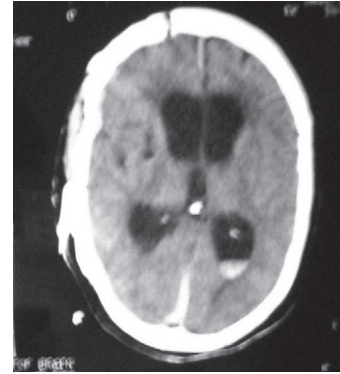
Non-contrast CT showing resolution of acute subdural hematoma and mass effect. There is increase in ventricular size with presence of intraventricular blood.
